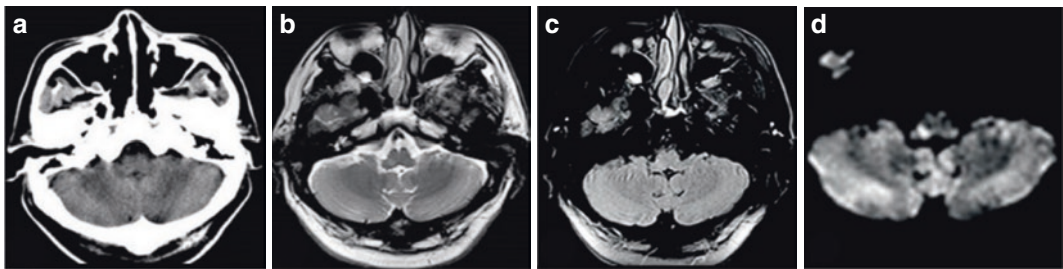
Acute medullary infarction. A 46-year-old female patient who presented with numbness and weakness in her left limbs for 4 h. Transverse plain CT scan shows no abnormalities (a). Transverse T_2 WI shows slight hyperintensity in the right dorsolateral medulla oblongata
